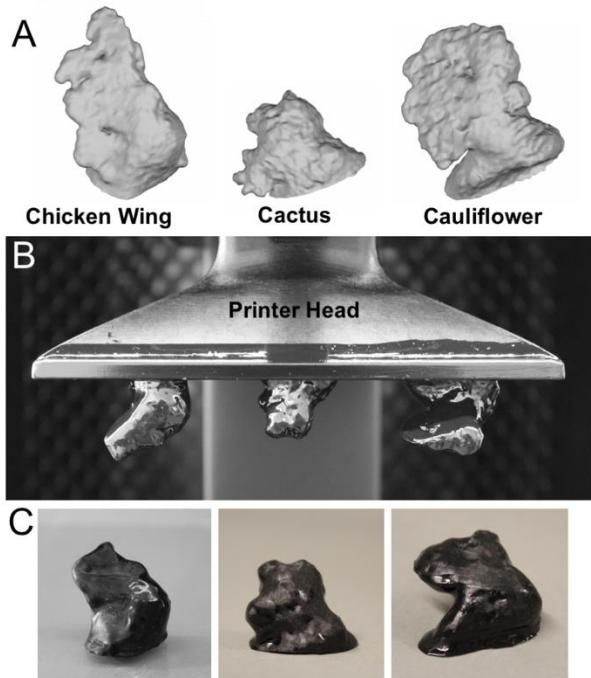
Multiple patient-specific occluders can be printed simultaneously. (a) CAD renderings of CT segmented LAA for three typically encountered LAA morphologies, Chicken Wing (CW), Cactus, and Cauliflower. (b) 3D printed morphologies *green bodies*. (c) Fully cured LAA occluders for three patient morphologies.
